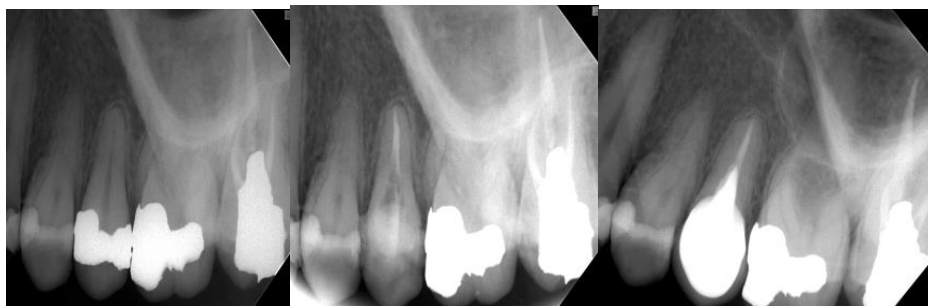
a) Left maxillary second premolar with previous extensive amalgam restoration and periapical lesion, b) RCT and obturation with cold ceramic, c) 2-year recall radiograph revealing approximate healing of the bone and normal PDL.
